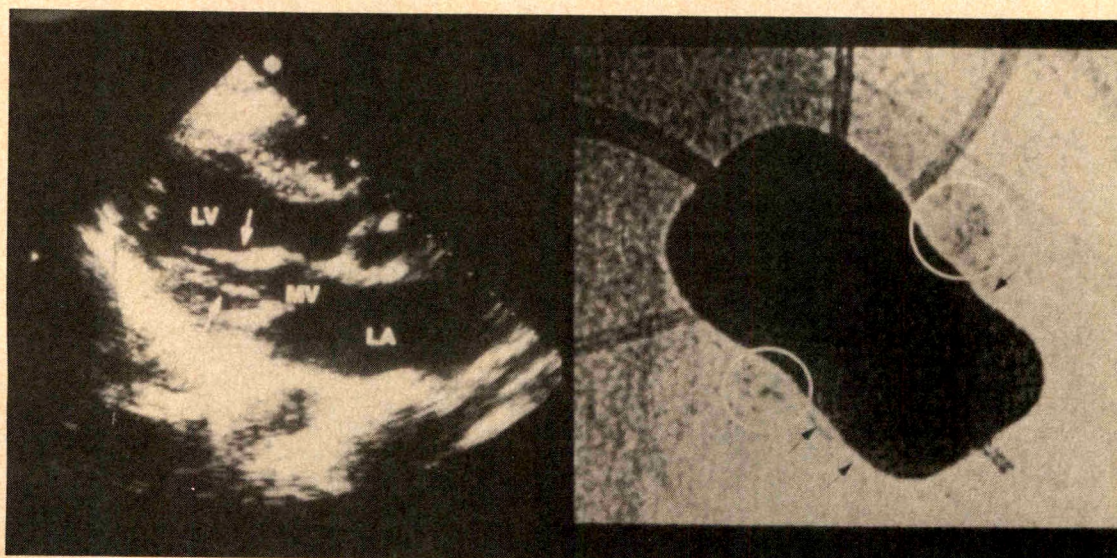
Left*, a long-axis view from 2-dimensional echocardiogram showing severe mitral subvalvular lesions. The chordae tendineae (white arrows) are shortened and severely thickened. *Right*, an angiographic view showing unusual contour of the distal half of the balloon during inflation. Its upper and lower walls are flattened (black arrows) due to compression from the severe subvalvular lesions. The valve is also calcified (white circles). LA = left atrium; LV = left ventricle; MV = mitral valve.
